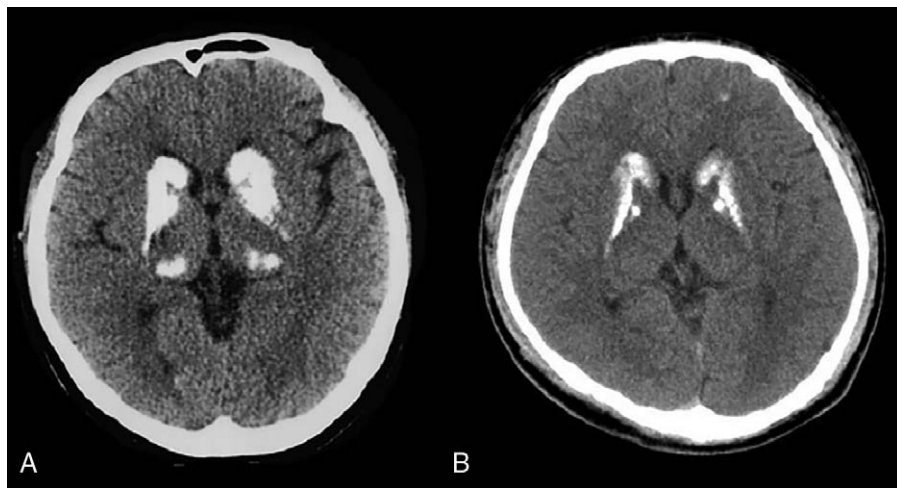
Head CT of the patient and her son showing calcification of basal ganglia. (A) Head CT of the patient shows calcification of bilateral calcification of basal ganglia and thalamus. (B) Brain CT scan of the son reveals calcification of bilateral calcification of basal ganglia. CT=computed tomography.
